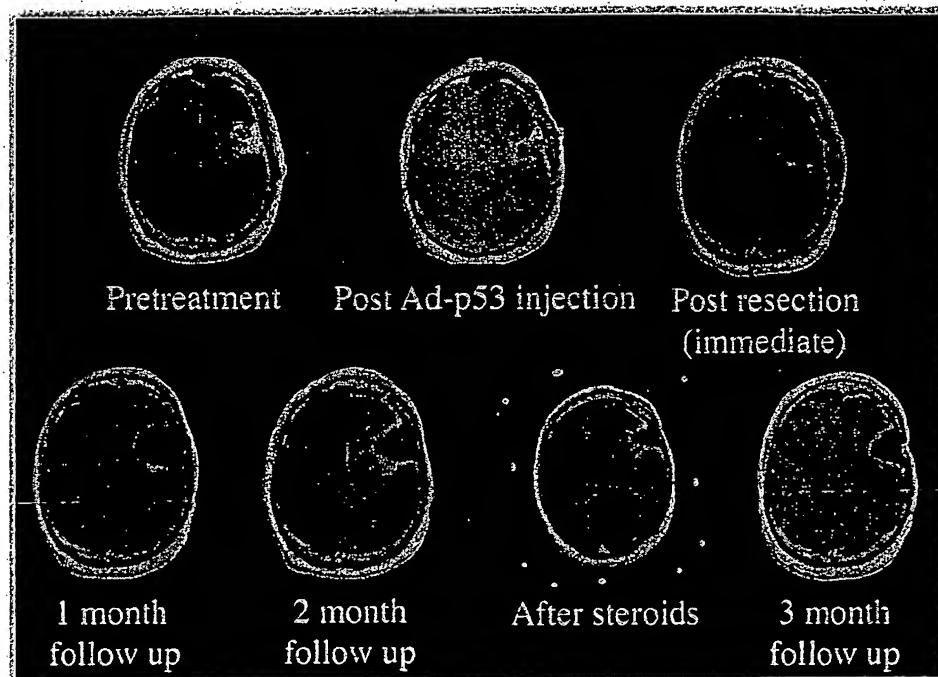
Serial T1-weighted postgadolinium magnetic resonance images (MRIs) of patient 8. Initial MRI demonstrates lesion in left frontal lobe. The catheter is evident on the poststereotactic-injection image. Postresection image shows a clean resection cavity. The one-month scan is stable, but the 2-month scan shows evidence of pericavity enhancing spikes; the patient had worsening speech. Treatment with corticosteroids (1 week) reduced the enhancement and improved the symptoms. By 3 months, the spike-like enhancement resolved.
